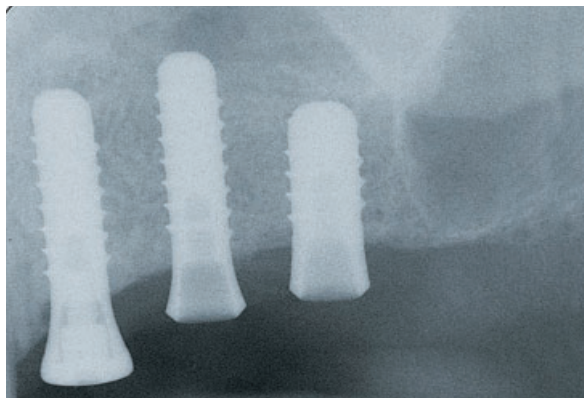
The corresponding radiograph confirms successful osseointegration of the three implants that are mostly located in augmented bone.
